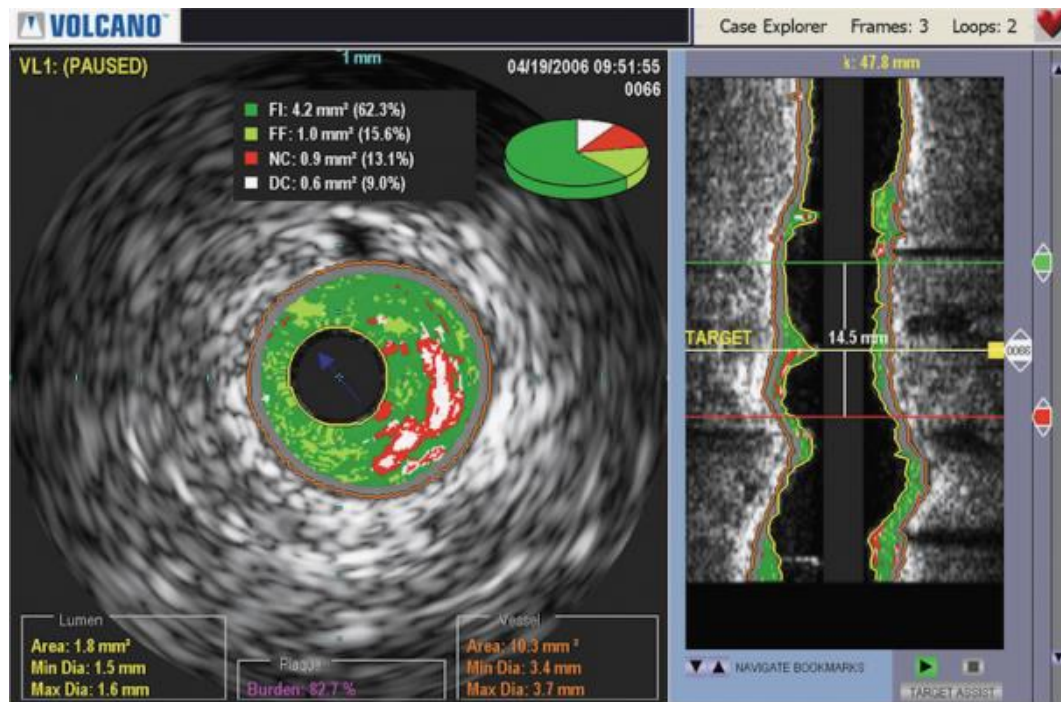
Intravascular ultrasound interface
